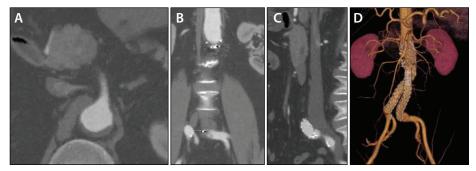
Postoperative CTA at 3-year follow-up showing no type I endoleak (A-D).
